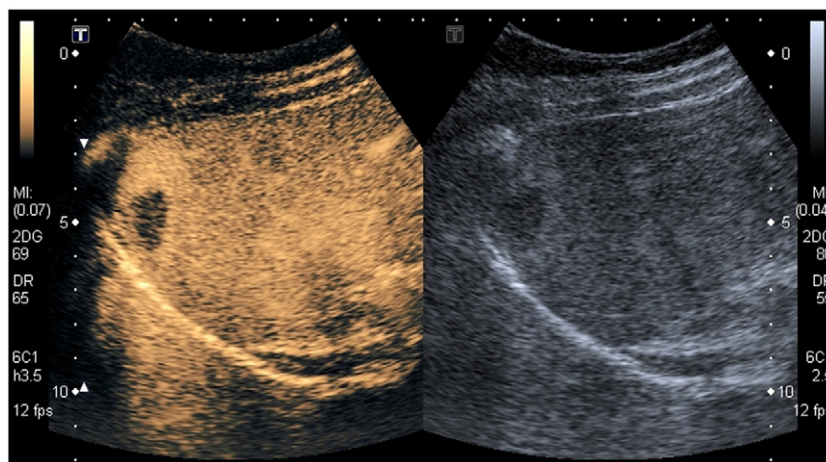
Ultrasound imaging of a human liver with microbubble contrast agents: non-linear mode preferentially showing bubbles (left) and standard linear B-mode image (right).
